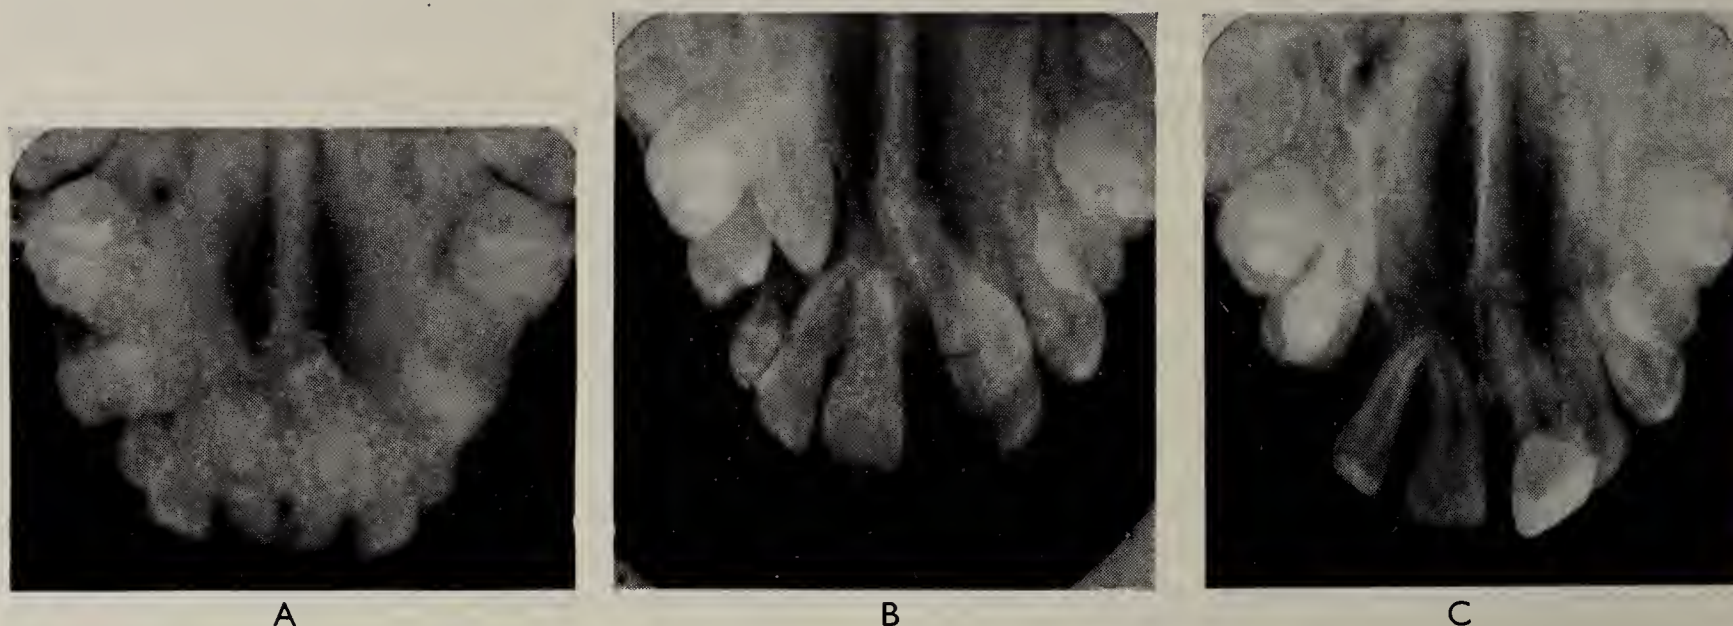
Case 1. Multiple supernumeraries. A, Preoperative X-ray. B, Twenty months later; before second operation. C, Five months after capping.
